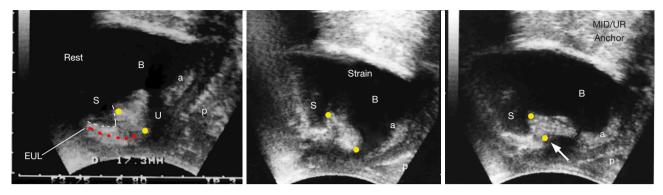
Transperineal ultrasound of a woman with SUI. Transperineal ultrasound of a woman with SUI. At rest (left frame). During straining (middle frame), PUL (small yellow circles) is stretched downwards; the a&p are stretched backward and downwards; the bladder neck and distal urethra are opened, and urine is lost. A hemostat (right frame white arrow) supports the PUL at the midurethra so that it does not extend as in the middle frame (yellow circles). Bladder neck and distal urethral closure are restored; a&p are firmly tensioned backwards/downwards. This is the action known to close the bladder neck. The distal urethra has been entirely closed. The two yellow circles mark the length of PUL extending from behind the lower border of the symphysis to the midurethra; red broken lines in the left frame mark the anterior wall of the distal urethra, which, in the right frame, appears to have been closed tightly from behind by the same forwards force as in *Figure 2*. White broken line, lower border of pubic symphysis. Reused from Petros P. The female pelvic floor function, dysfunction and management according to the Integral Theory. 3rd ed. Heidelberg: Springer Berlin; 2010. With permission from Peter Petros; retains ownership of the copyright. EUL, external urethral ligament; S, symphysis; B, bladder; U, urethra; a, anterior wall of the vagina; p, posterior wall of the vagina; MID, midurethral anchor; UR, urethra; SUI, stress urinary incontinence; PUL, pubourethral ligament; a&p, anterior and posterior walls of the vagina.
